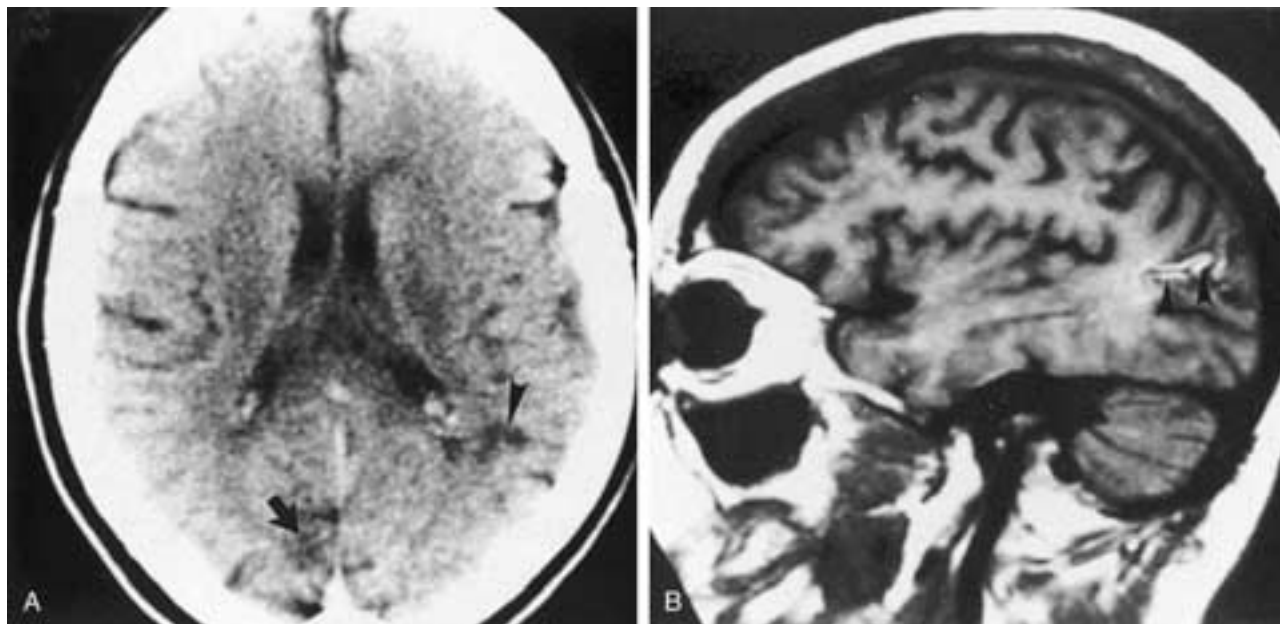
Hemorrhagic infarcts of the parietal and occipital lobes. A, Axial CT image without contrast shows a vague hypodensity in the right occipital lobe (arrow) and another vague hypodensity (arrowhead) in the left parietal lobe. B, Sagittal T1-weighted image shows hyperintense methemoglobin (arrowheads) in the cortex.
